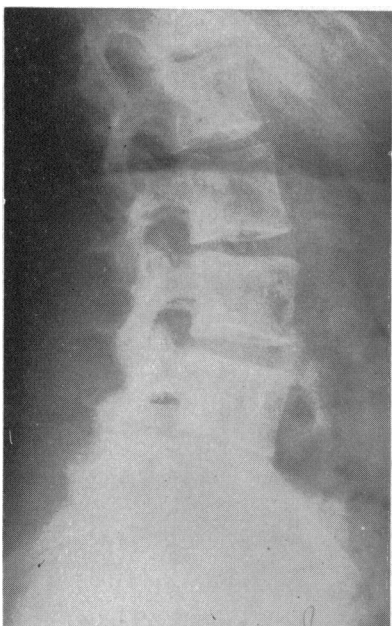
Radiograph of lumbar spine, February 9, 1953.
